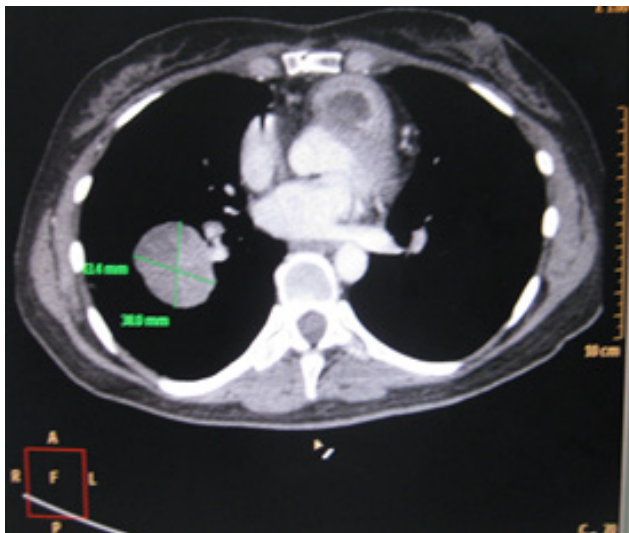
Chest CT Scan of a 38 year old female taken 8 months after excision of pulmonary artery mass and immune cell therapy. There was an interval increase in the mass at the superior segment of right lower lobe and an interval appearance of another ovoid mass in the aortopulmonary window causing extrinsic compression to the left pulmonary artery.
